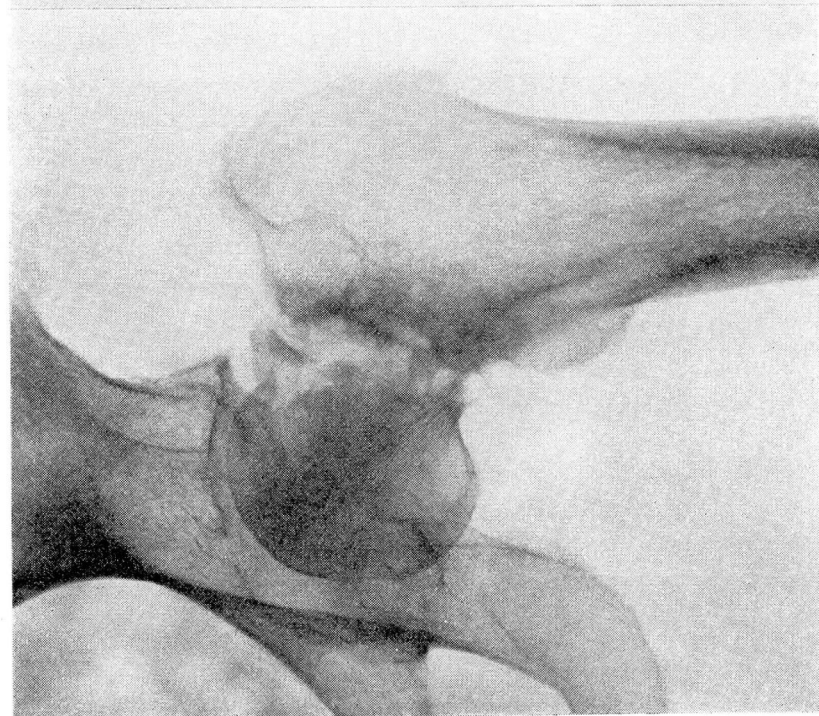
Case 1. Roentgenogram showing ununited fracture before operation.
